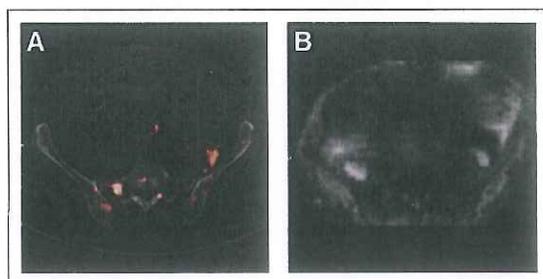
A 58-y-old woman with pancreatic NET. A 6-mm sacral metastasis was detected exclusively by ^{68}Ga -DOTATATE PET/CT (A) and was confirmed retrospectively by dedicated MR imaging; WB DWI (B) did not detect this lesion.
